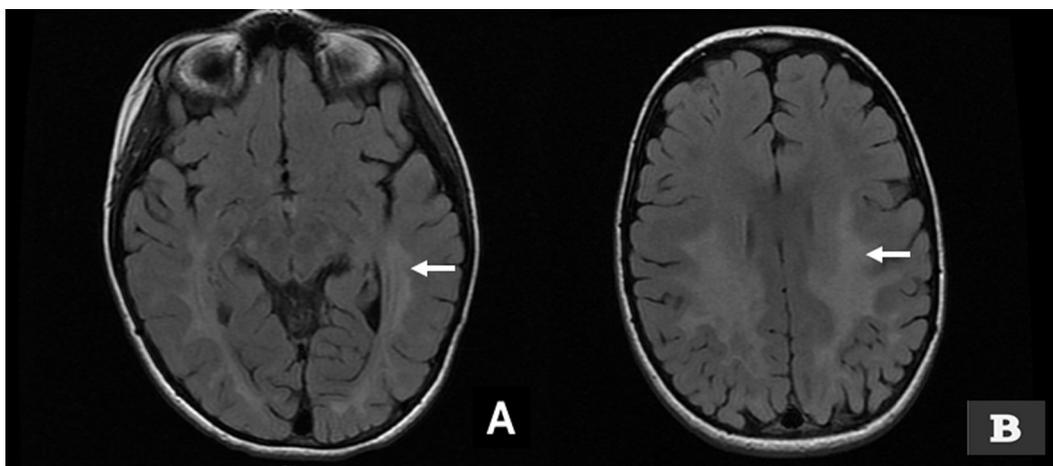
Magnetic resonance imaging of the brain, axial images. (A and B) (Fluid-attenuated inversion recovery) T2-hyperintense signal in the splenium of the corpus callosum and the peritrigonal deep white matter along the occipital horns of the lateral ventricles, extending into the temporal lobes and corona radiata bilaterally (white arrows). Post-gadolinium T1-weighted image showing subtle enhancement along the left parietal leading edge in the subcortical deep white matter (not shown).
